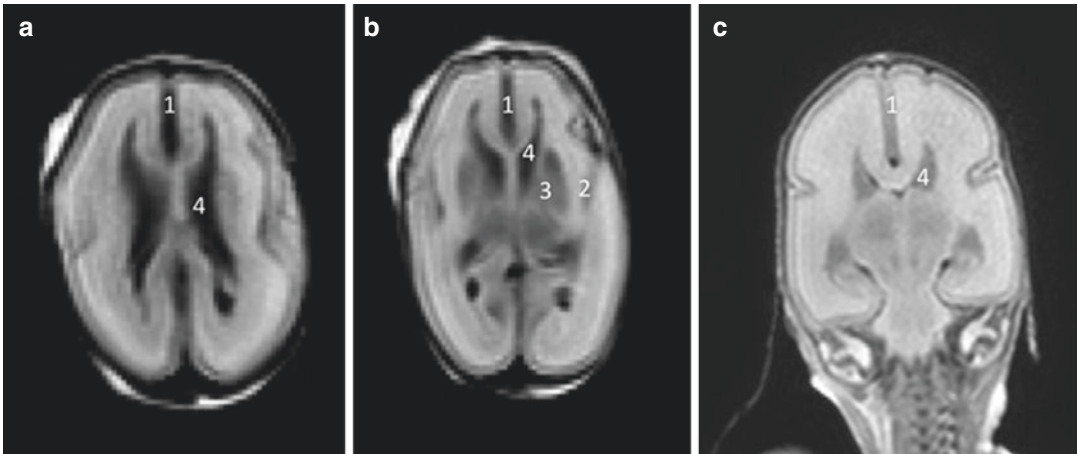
Post-mortem MRI axial (a, b) and coronal (c) T2w TSE of a 20-week-old foetus; in these planes are clearly visible interhemispheric fissure (1), Sylvian fissures (2), basal ganglia (3) and lateral ventricles (4)
